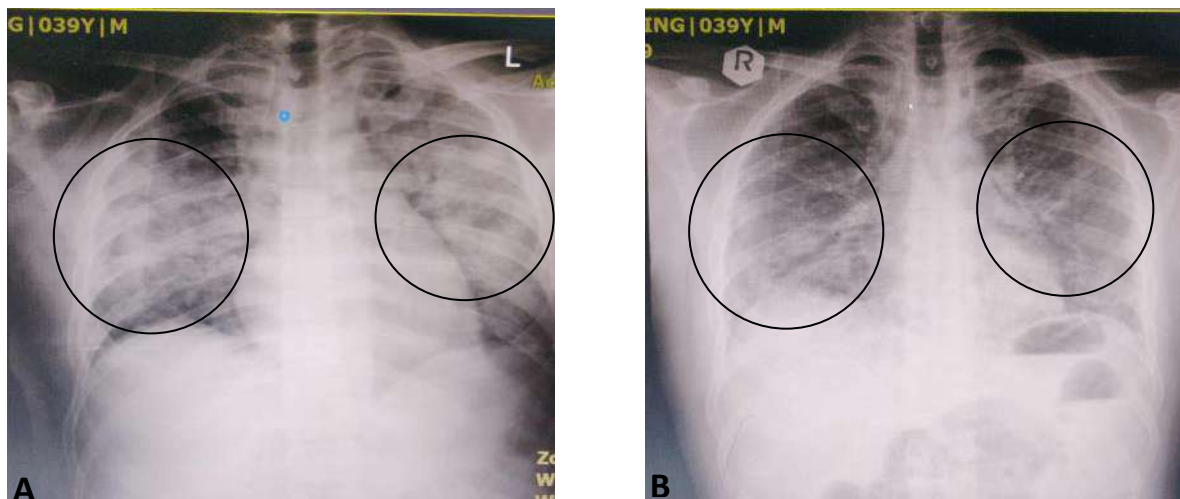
Chest X-ray on A) day 0 of treatment and B) day 14 of treatment
